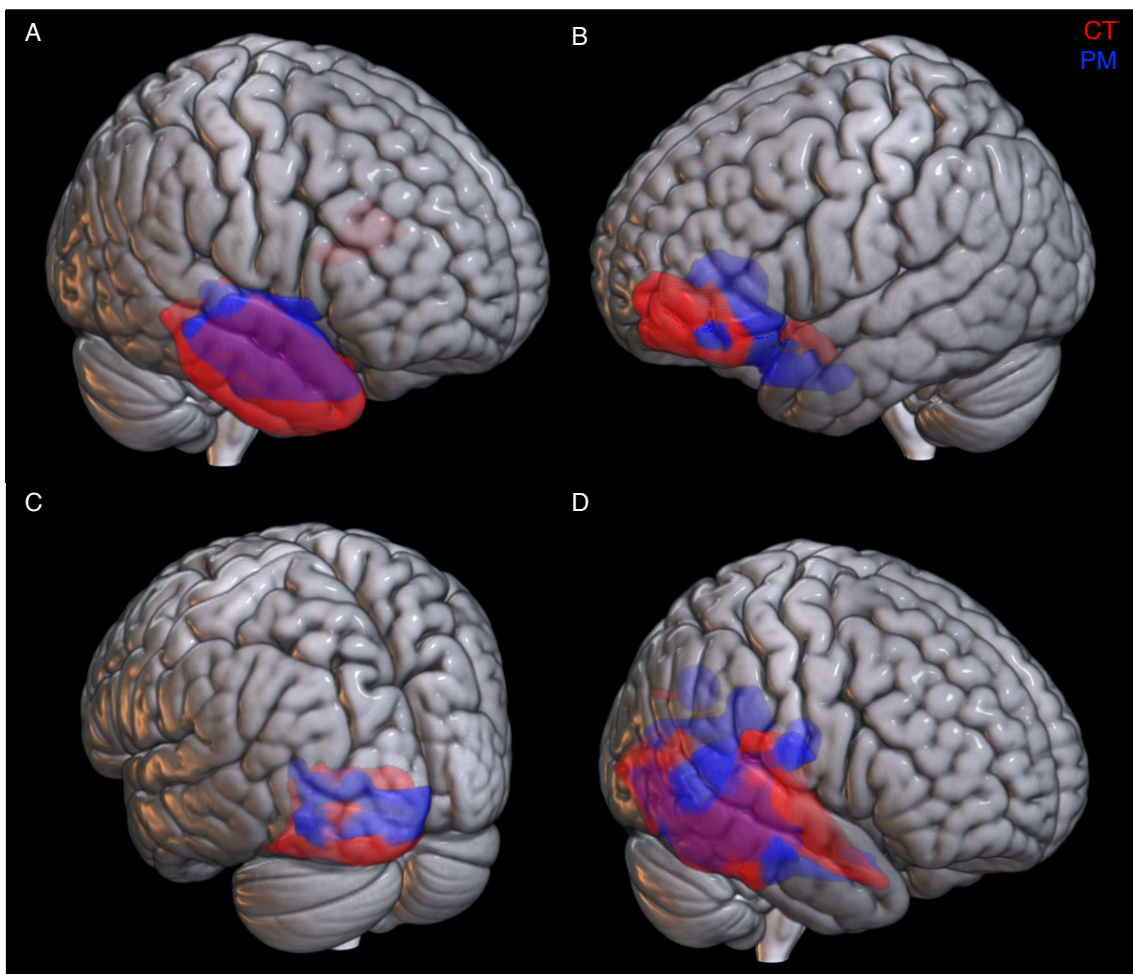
Structural validation of the novel lesion reconstruction method. Lesion reconstructions generated from CT head radiographs (red) and post-mortem photographs (blue) in four cases with both resources available.
